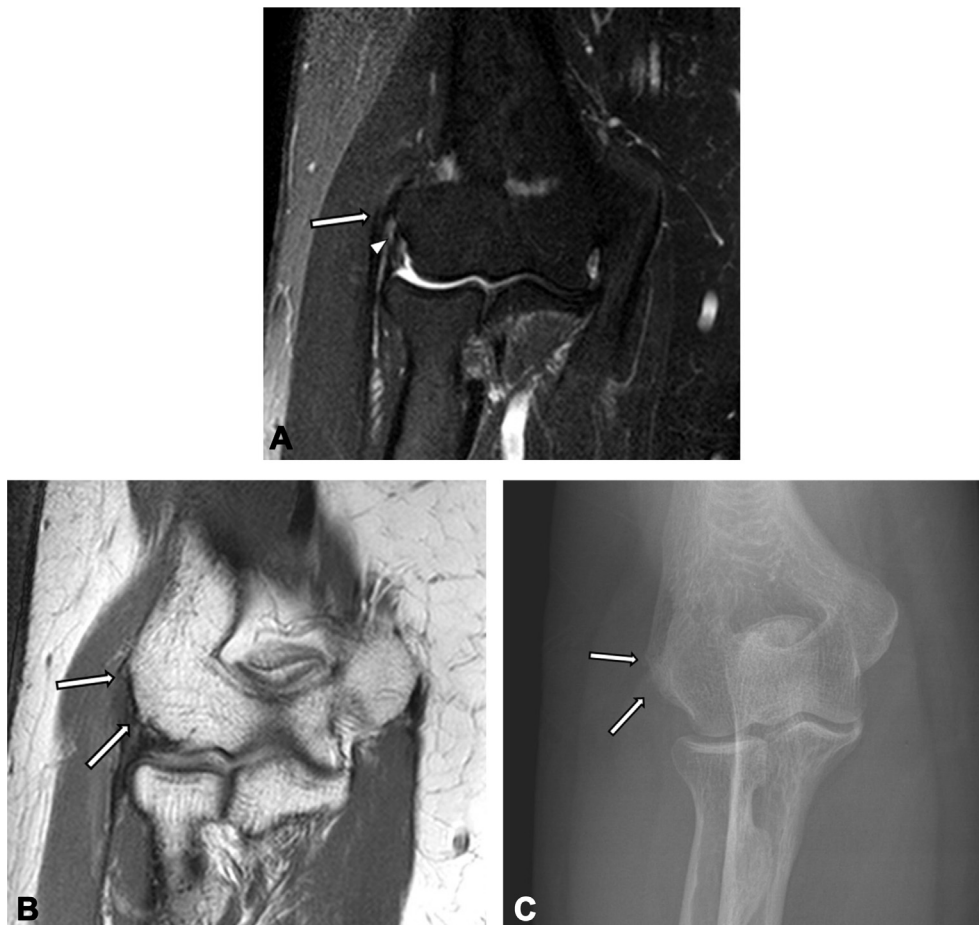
A 60-year old female with right elbow pain for 5 weeks. A. Coronal fat-suppressed FSE T2-weighted image showing mild thickening of the proximal portion of the common extensor tendon with increased signal intensity (arrow), suggesting mild injury. Irregular thickening with increased signal intensity in the proximal portion of the lateral collateral ligament (arrowhead) is also noted, suggesting mild injury. B and C. Coronal PD FSE image and oblique radiograph showing cortical irregularity of the lateral epicondyle (arrows), a finding suggestive of enthesophytes.
